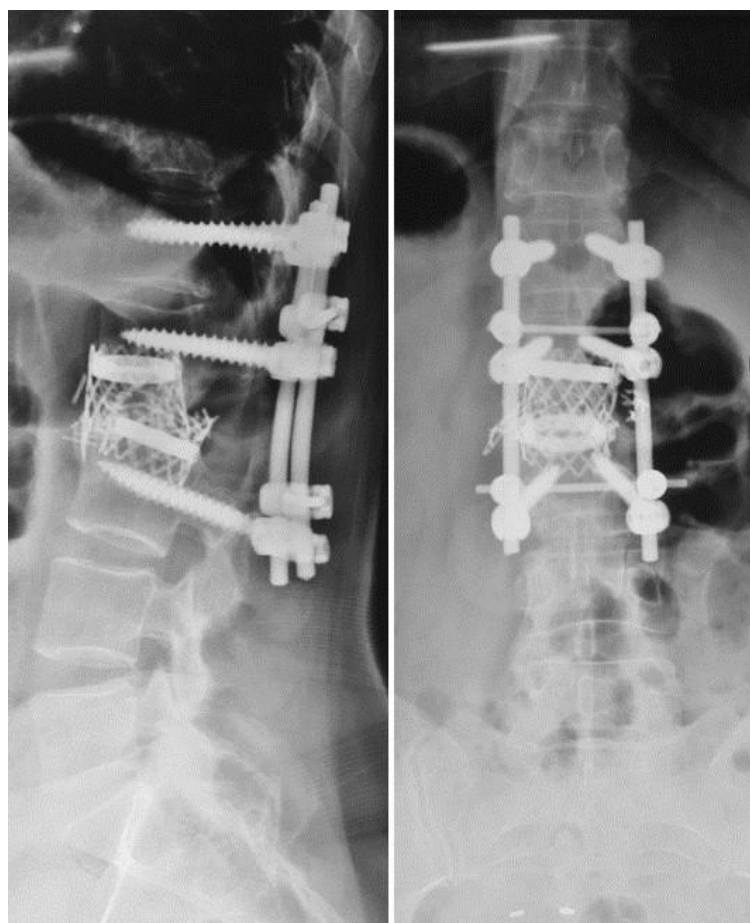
Radiographic follow-up ten years postoperatively demonstrates TMC fracture and collapse with consequent segmental kyphosis.
